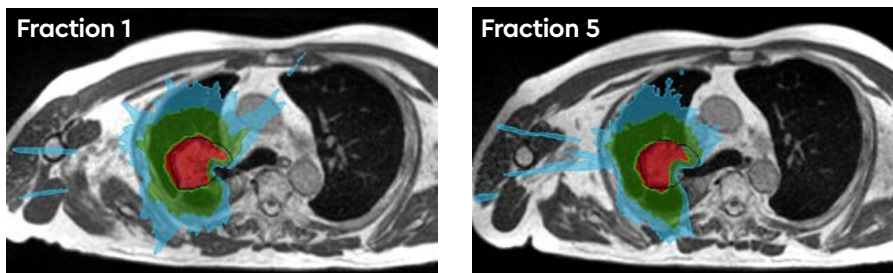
Daily re-contouring of a patient with central lung tumour. MRI scans from fraction 1 and fraction 5 show the extent of movement and variation and subsequent re-planning during adaptive treatment
